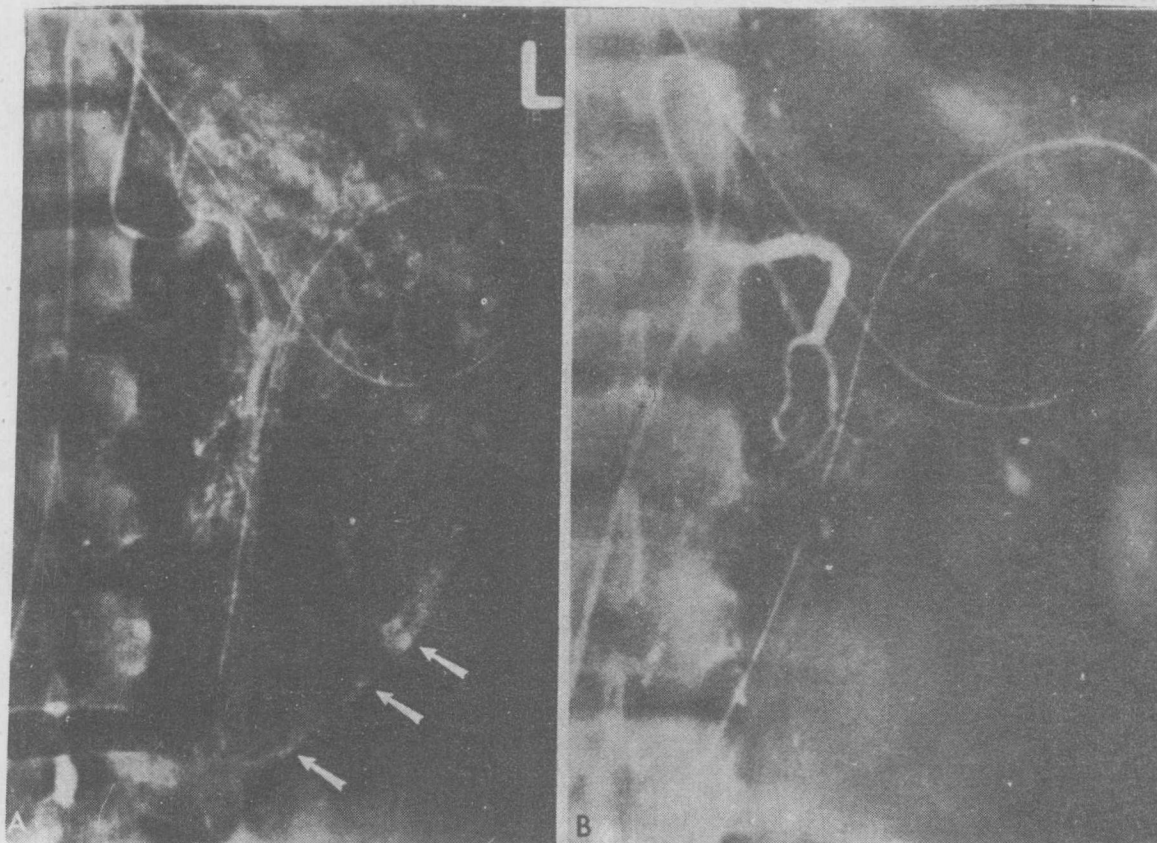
Bleeding from acute hemorrhagic gastritis in patient with diffusely metastatic breast carcinoma. A, Radiograph from late phase of the left gastric arteriogram shows diffuse gastric mucosal hyperemia. Areas of punctate contrast extravasation are seen from superficial erosions along the greater curvature (arrows). B, Following administration of vasopressin at 0.2 U/min for 20 minutes into the left gastric artery, there is excellent vasoconstriction and cessation of the bleeding.
